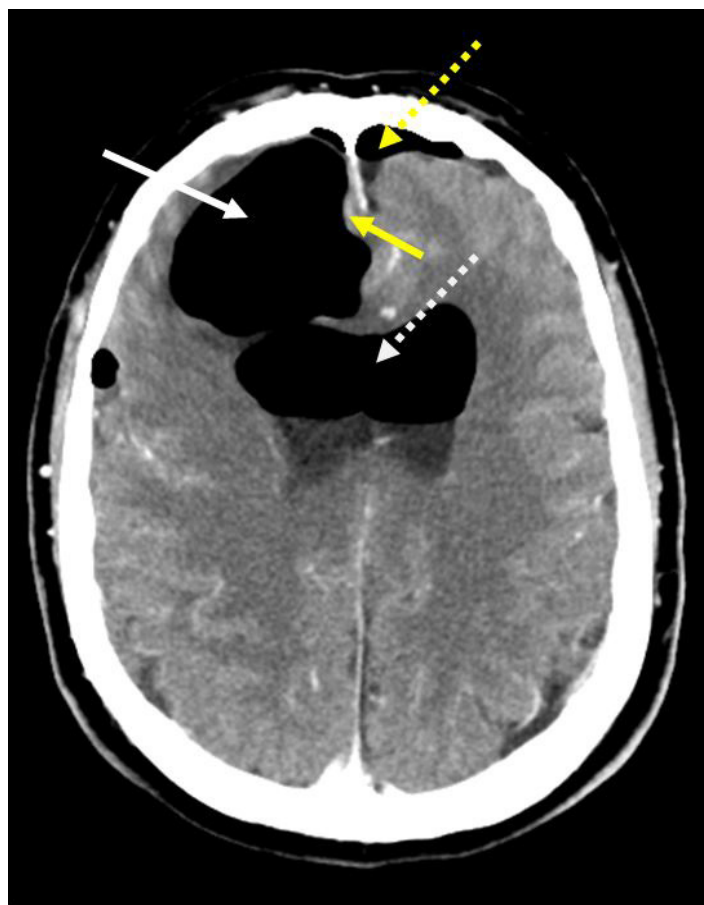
Computed tomography (axial view) of the brain demonstrating extensive, right greater than left, frontal pneumocephalus (solid white arrow), subarachnoid (yellow dotted arrow) and bilateral frontal ventricular horn gas (white dotted arrow) without midline shift. The CT also demonstrates minimal subdural blood (yellow arrow) along the inferior-anterior margin of the interhemispheric fissure adjacent to the gyrus rectus.
